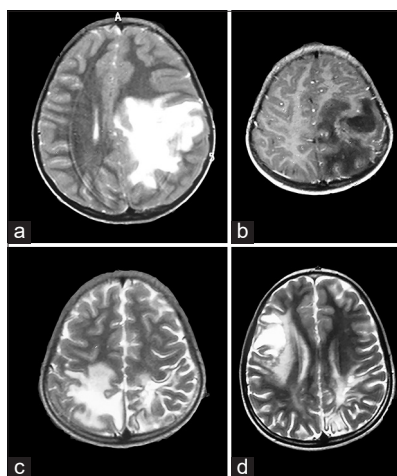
(a) T2-weighted axial magnetic resonance imaging of the brain shows large hyperintense lesion in the white matter of the left parieto-occipital lobe during the first attack of tumefactive demyelination. (b) Postgadolinium T1-weighted axial magnetic resonance imaging section showing peripheral incomplete enhancement. (c) T2-weighted axial magnetic resonance imaging of the brain during the second attack shows the appearance of a new T2 hyperintense lesion in the right parieto-occipital lobe; there is evidence of gliosis in the left occipital lobe. (d) T2-weighted axial magnetic resonance imaging of the brain during the third attack shows a lesion in the right frontal lobe, with resolution of the right occipital lesion (A in the figure indicates anterior)
